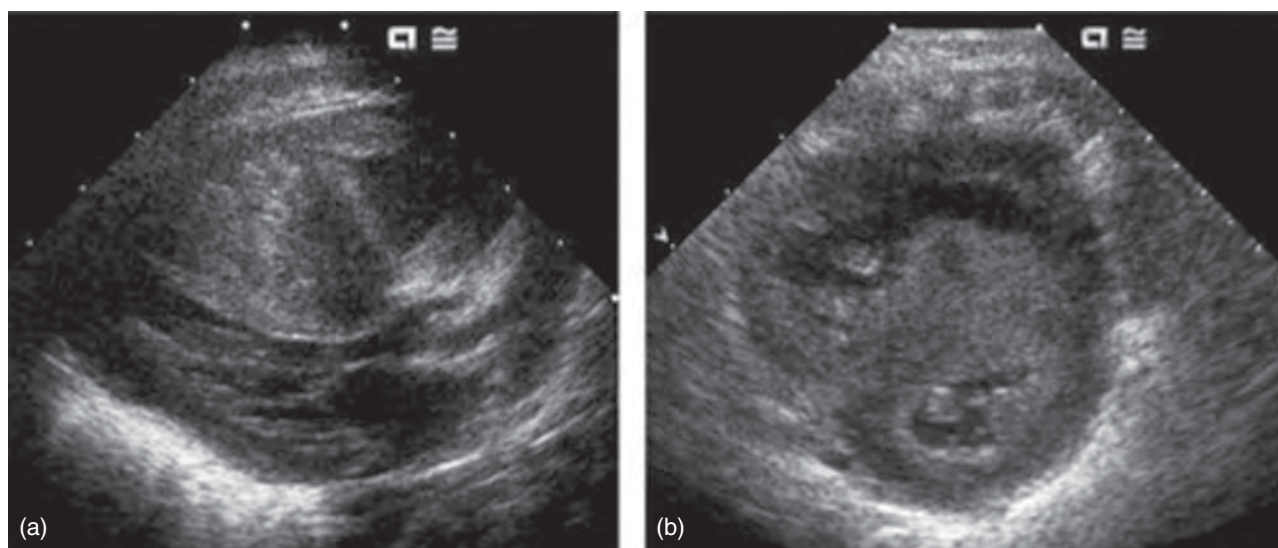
Neonatal hypertrophic cardiomyopathy associated with maternal diabetes. (a) Parasternal long axis and (b) short-axis images demonstrate asymmetric septal hypertrophy with near obliteration of the left ventricular cavity. The development of hypertrophy is associated with maternal hemoglobin A1C levels >6 g/dL in the latter part of gestation and generally resolves slowly after birth. Source: Jaeggi *et al.* [3]. Reproduced with permission of John Wiley & Sons Inc.
